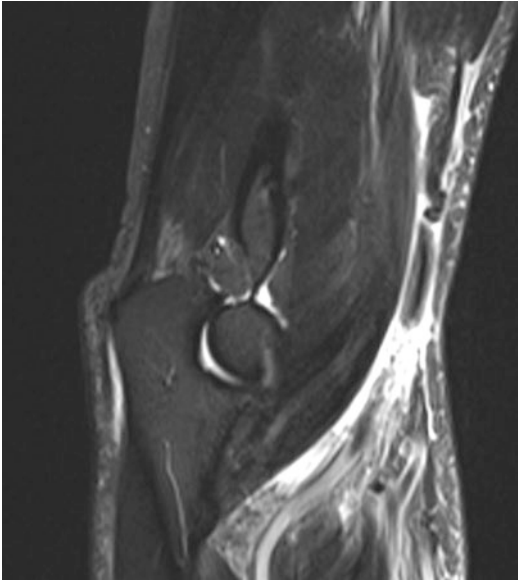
MRI of an elbow depicting a distal biceps brachii tendon rupture
